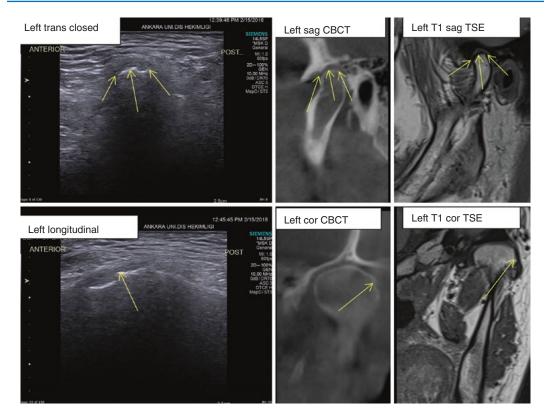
Closed mouth US, CBCT, and MRI of the same patient with degenerative bone changes of left TMJ
